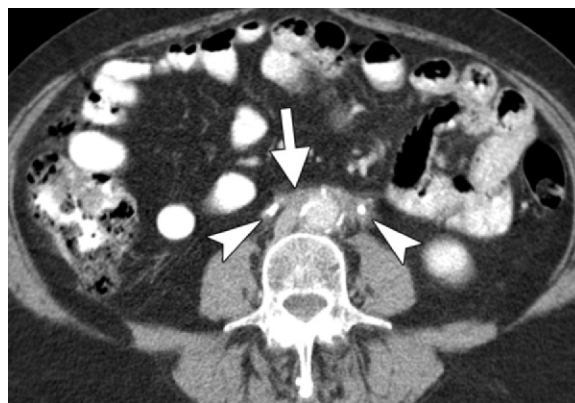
RPF in a 56-year-old man. Axial CT image obtained 60 seconds after contrast material administration shows a plaque-like area of attenuation (arrow) surrounding the aorta and IVC. Peripheral infiltration encases both ureters (arrowheads) and does not separate the aorta from the spine, findings indicative of benign RPF. Note the bilateral ureteral stents.
